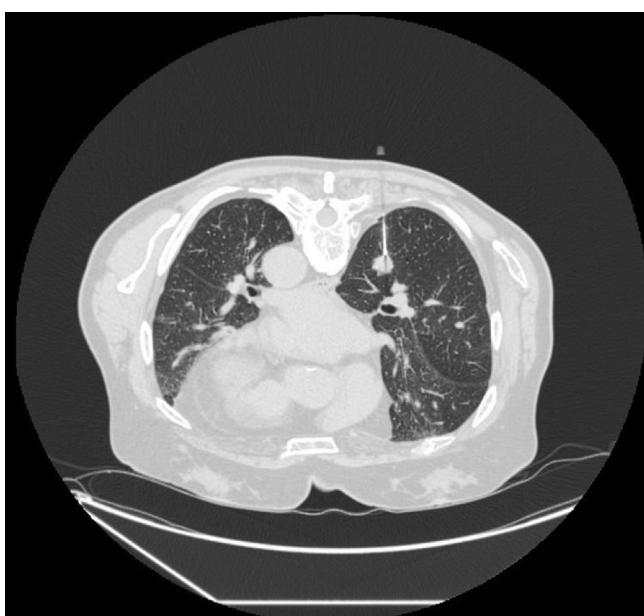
A CT scan of a needle inserted into the lung to obtain a sample for biopsy.
